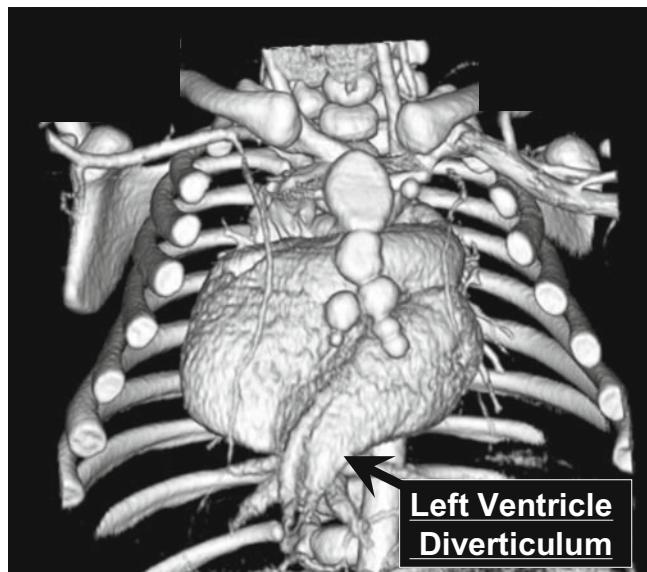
Three-dimensional computed tomography (3D-CT) examination. The left ventricular diverticulum was located in front of the left hepatic lobe
